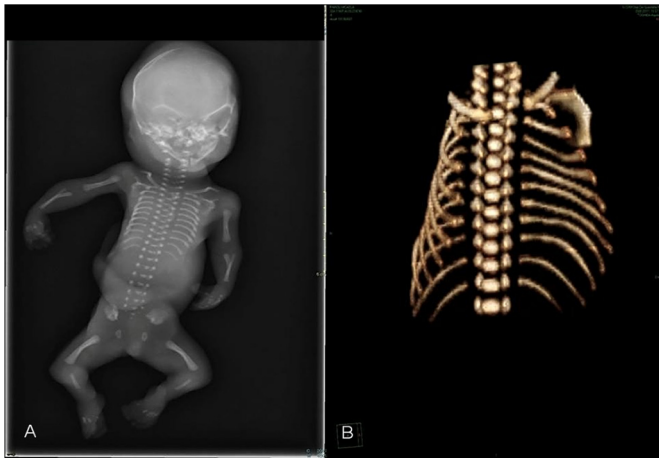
Case 3. (A) Radiography confirmed reduced ossification of cranial bones and bilateral bowing of the femurs. (B) Detail of the thoracic cage by three-dimensional computed tomography.
